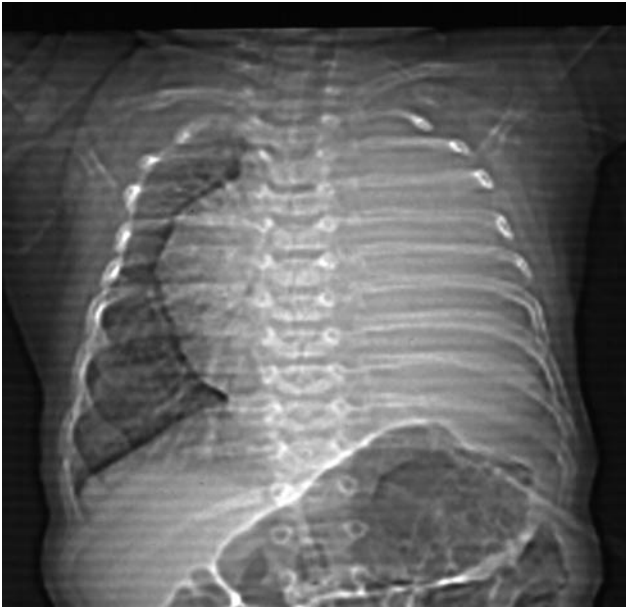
Preoperative chest radiograph showing gross cardiomegaly
